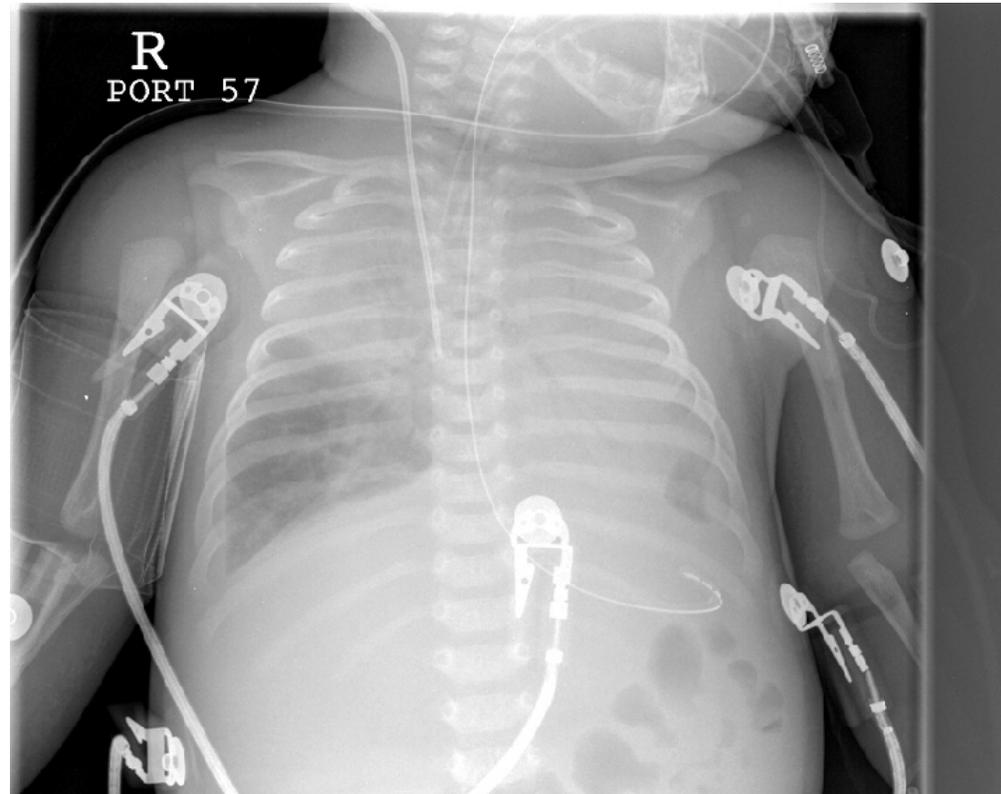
Figure Legend: Pertussis pneumonia in a 7-year-old who was exhausted from persistent coughing. Obliteration of cardiac borders on the chest radiograph is a common radiographic change of pertussis pneumonia.
